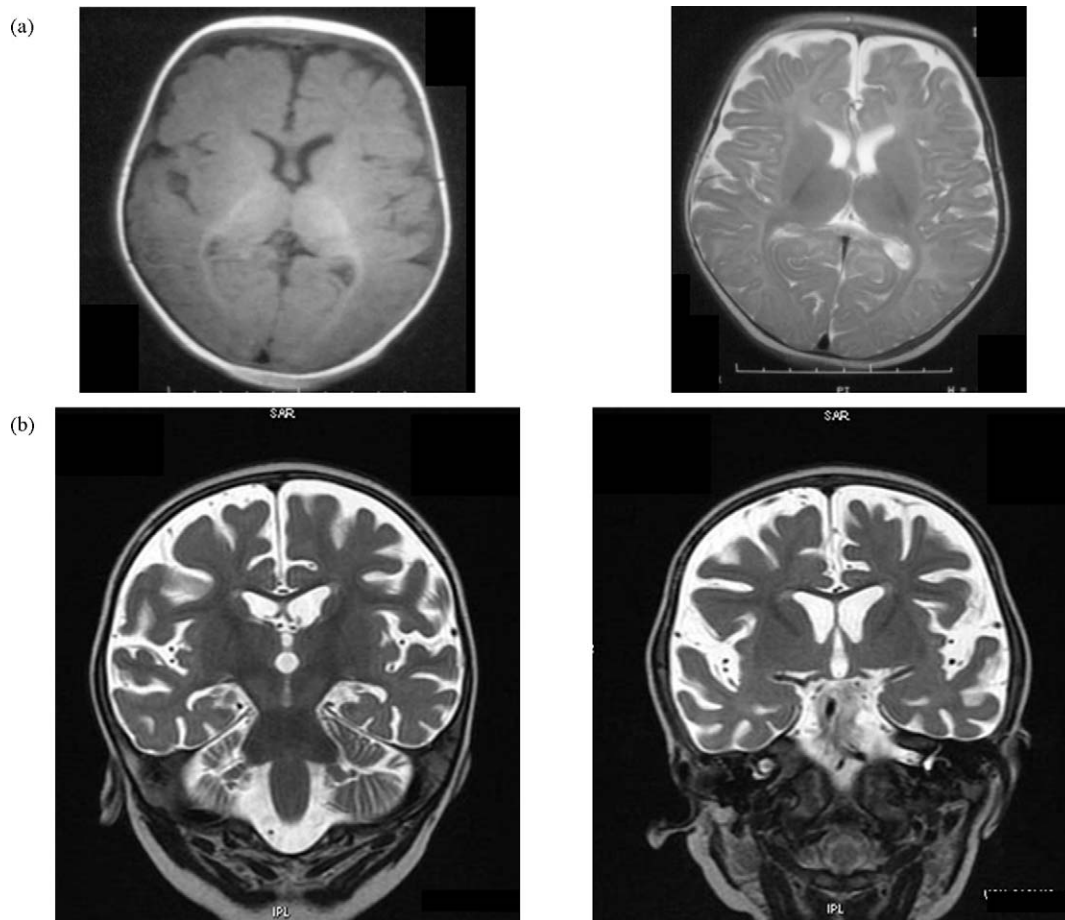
MRI of patient 1 before (age 3 months) (a) and 2 months after complicated SE (age 13 months) (b).
